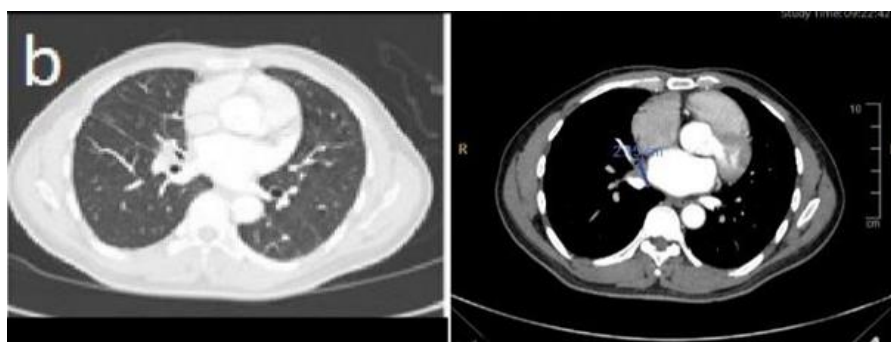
thoracic CT scan examination on September 6th, 2021, first RECIST.
